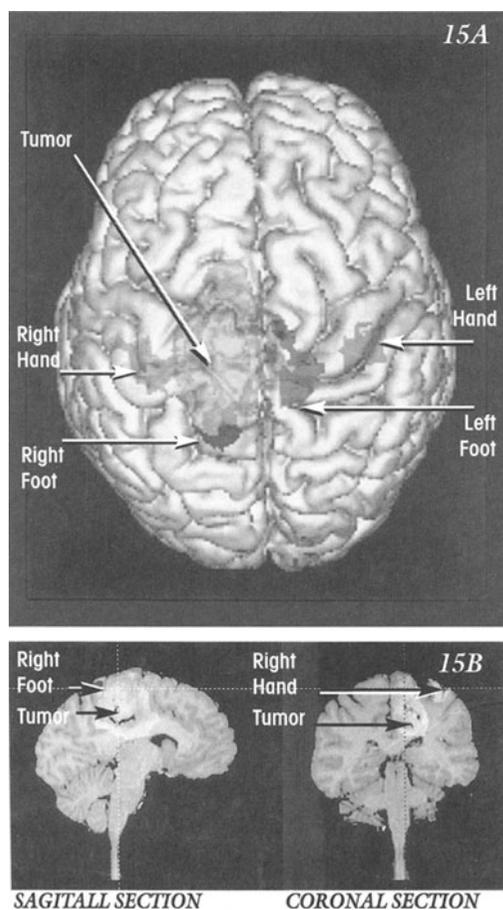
Functional MRI. This 33-year-old woman had a 2-year history of focal seizures involving the right foot and arm. A large area of the left premotor and motor cortex is involved by a grade 2 astrocytoma A) The relation of the areas activated by right hand or foot movements to the intrinsic brain tumor are indicated. B) Comparison of normal hemisphere to abnormal hemisphere. Note the displacement of the arm and leg areas by the tumor. Courtesy of Drs. B.R.Buchbinder, H. Jiang, G.R. Cosgrove A Cole, D. Hoch and R. Hill at the Massachusetts General Hospital Epilepsy Center.
